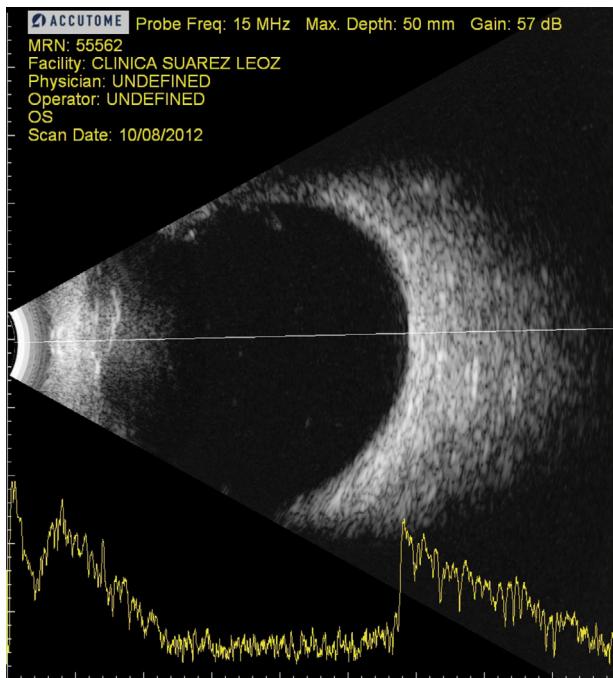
Ocular ultrasound of the LE. No significant injuries, no evidence of optic nerve drusen.
